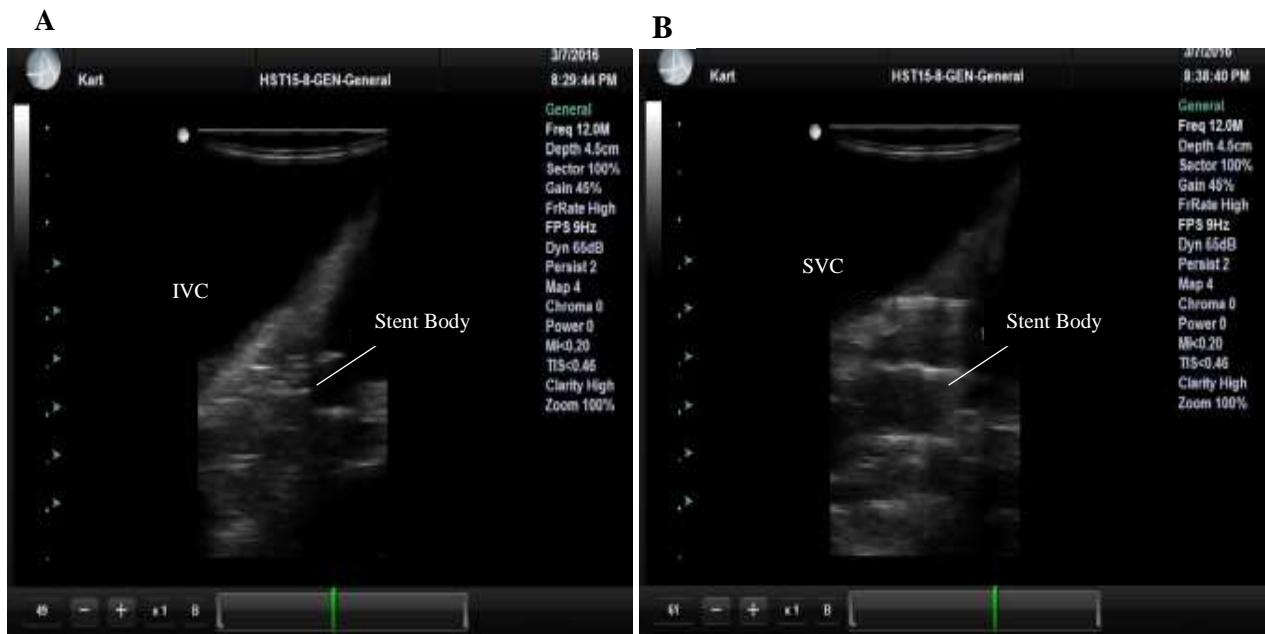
Echocardiographic images showing the successful deployment of the caval valves IVC (A) and SVC
